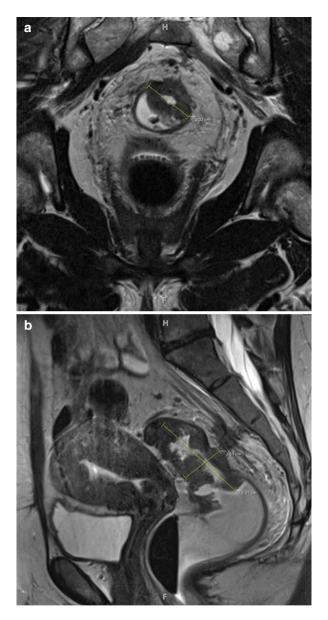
(a and b). The main concept in the use of MRI to stage rectal cancer is to obtain high-resolution images within small field-of-view thin sections with fast/turbo spin echo (FSE/TSE) T-2-weighted axial and coronal views of the rectum.
